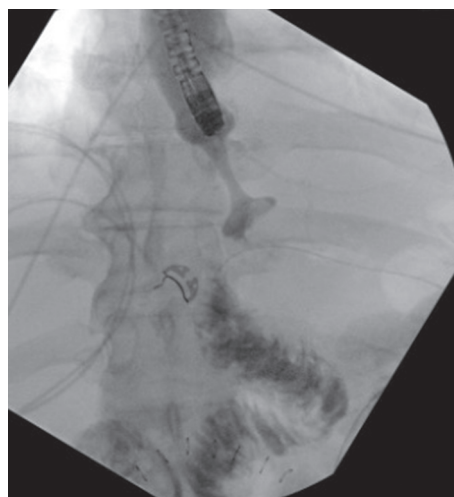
X-ray fluoroscopy during endoscopic EJ anastomosis procedure showing stent in place from case 5.
